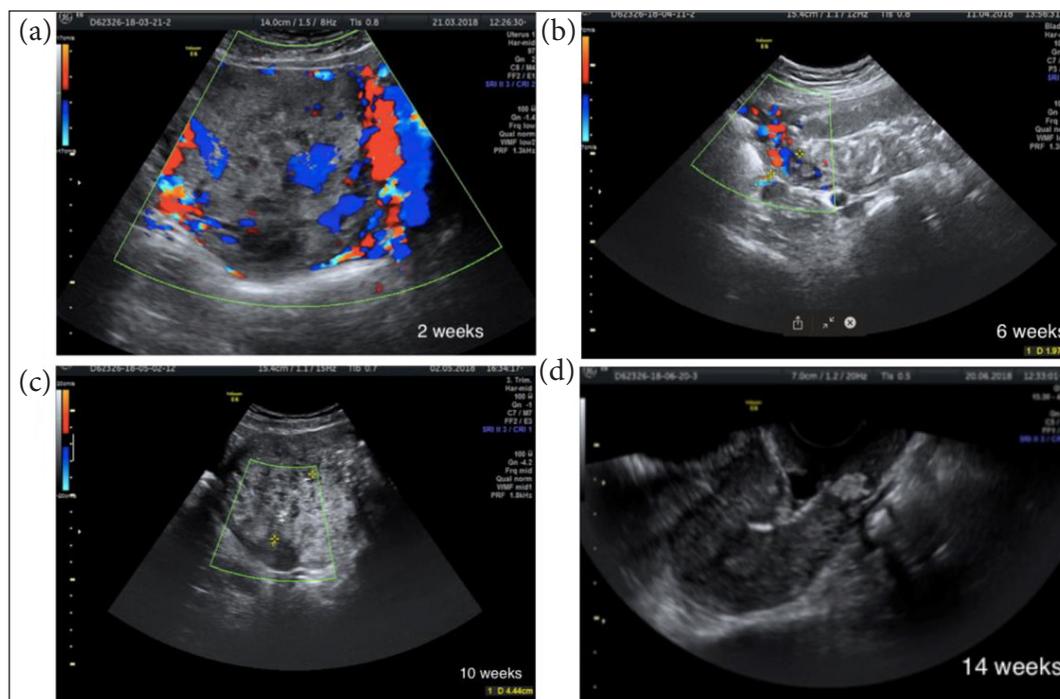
Ultrasound images showing resorption of placenta in case 2. Two weeks after Caesarean section on colour Doppler, the placental tissue has and increased blood flow (a); six weeks after the operation, a decrease in blood flow is prominent (b); after ten weeks, no placental vascularization was observed (c); 14 weeks after the operation a complete resolution of the placenta was diagnosed (d)
